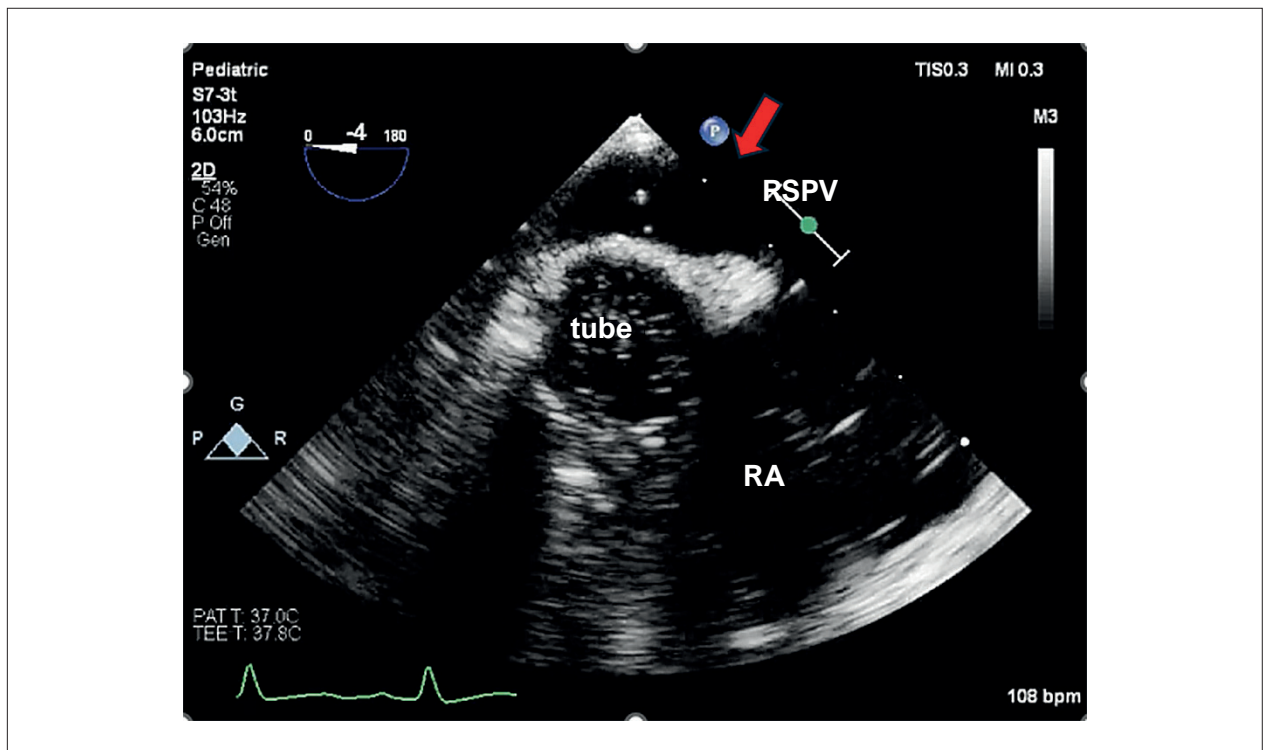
Transesophageal echocardiography in a patient following extracardiac Fontan surgery. The arrow indicates the RSPV, where microbubbles are observed after injection of agitated saline via peripheral IV access, which suggests the presence of pulmonary microfistulas. IV: intravenous; RA: right atrium; RSPV: right superior pulmonary vein.
